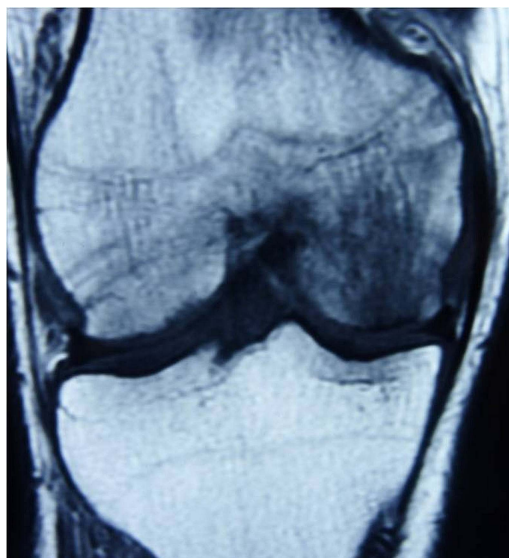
T1-weighted images of the MRI showing hypointense area involving the medial femoral condyle of the knee.
